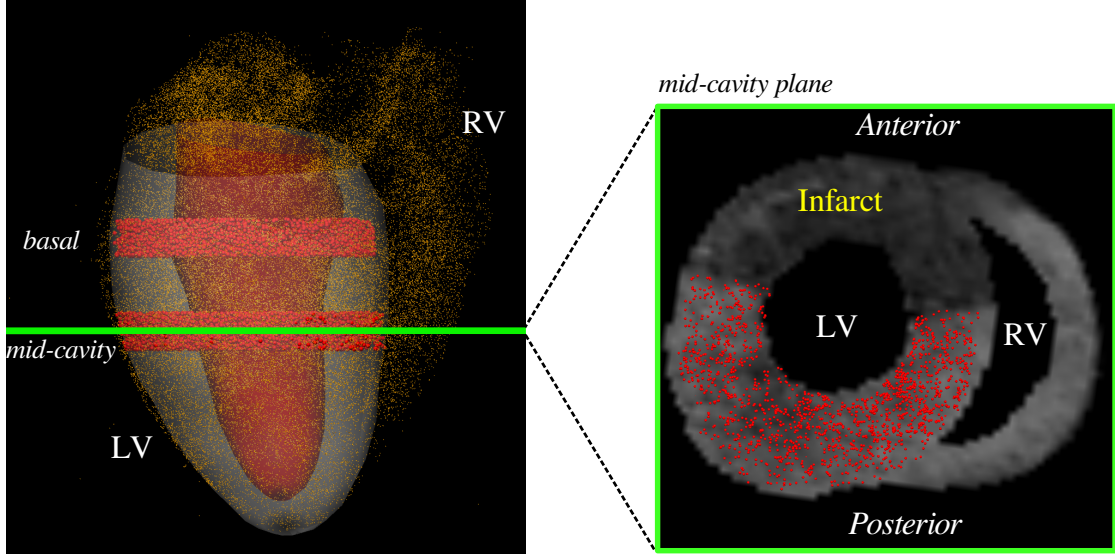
The LV mesh and microspheres shown from a posterior view. Microspheres injected into the heart distribute across both ventricles, indicated by the faint orange points (left). The larger microspheres shown in red are within the LV mesh and also within the 8mm width of the mid-cavity and basal DCE-MR image slices. A short-axis base-to-apex view of the microspheres within the mid-cavity DCE-MRI slice (marked in green on the left) shows the boundaries of the ischemic region provide correspondence between the microspheres and the DCE-MR image. (Note that the LV and RV cavities and the surrounding water bath have been manually removed for clarity.)
